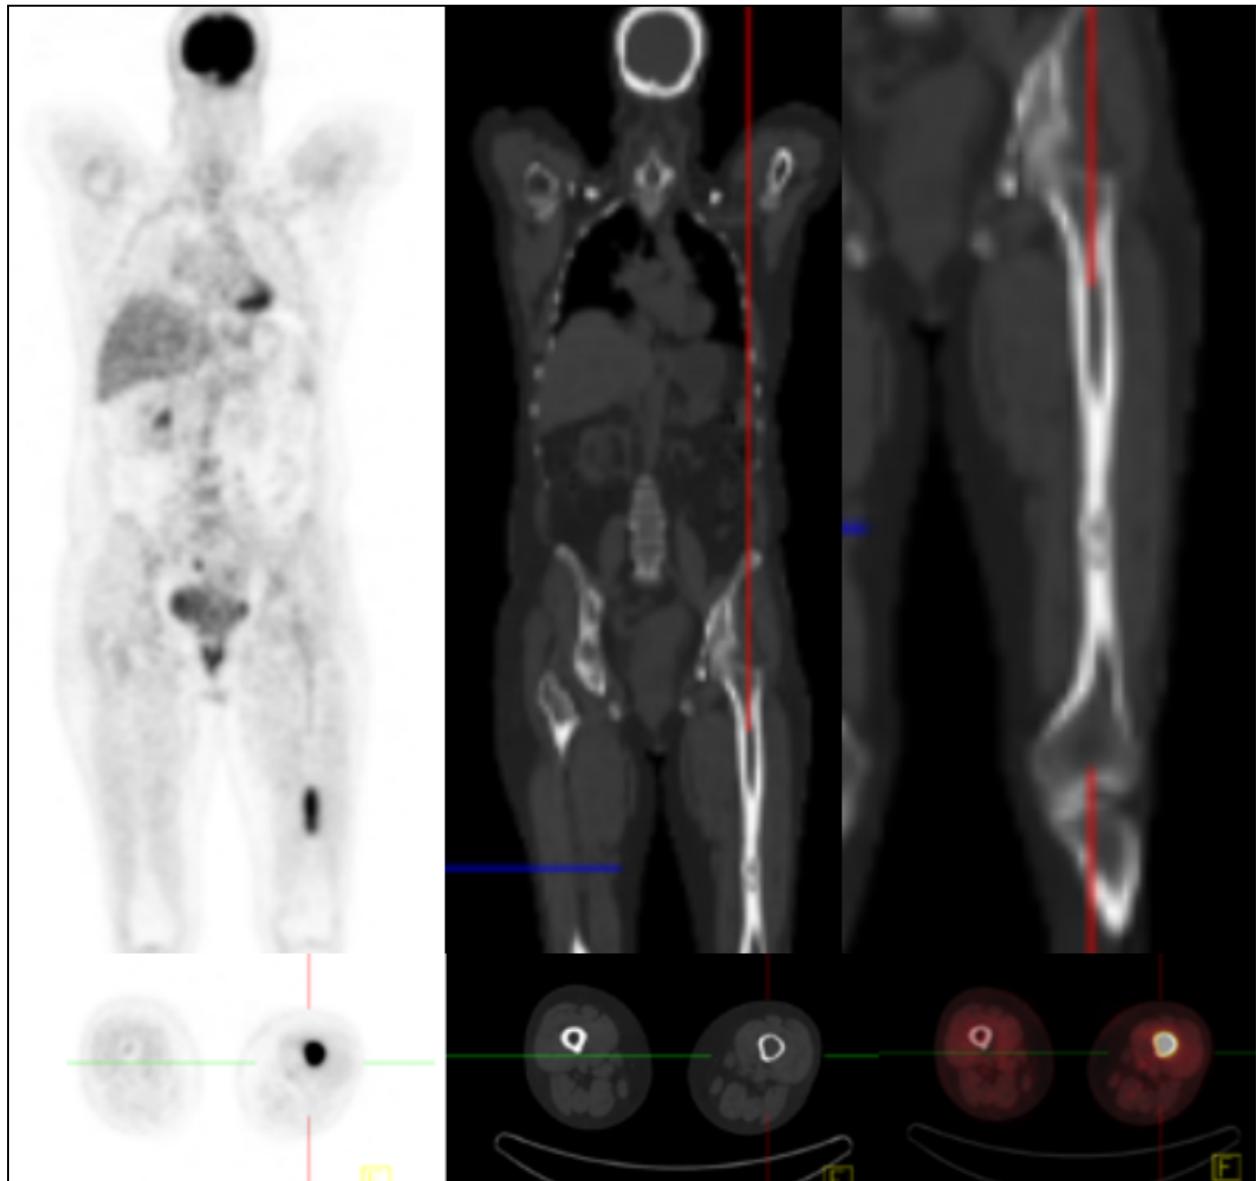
PET/CT image showing a hypermetabolic lesion in the mid-third of the left femoral diaphysis
